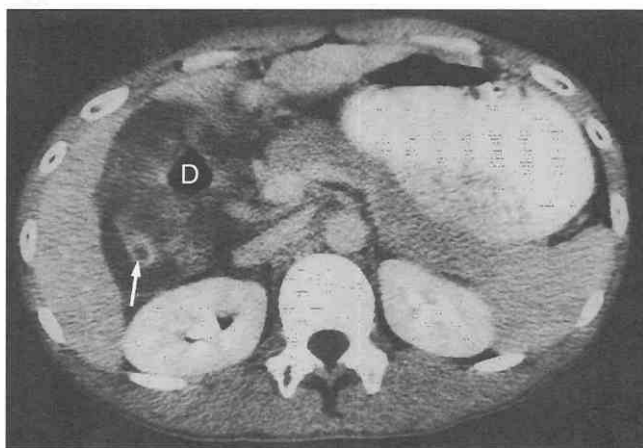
Confined duodenal ulcer perforation. CT scan shows edematous bowel wall thickening of the duodenum with an ulcer crater (arrow). A small amount of fluid is collected in the paraduodenal space.
